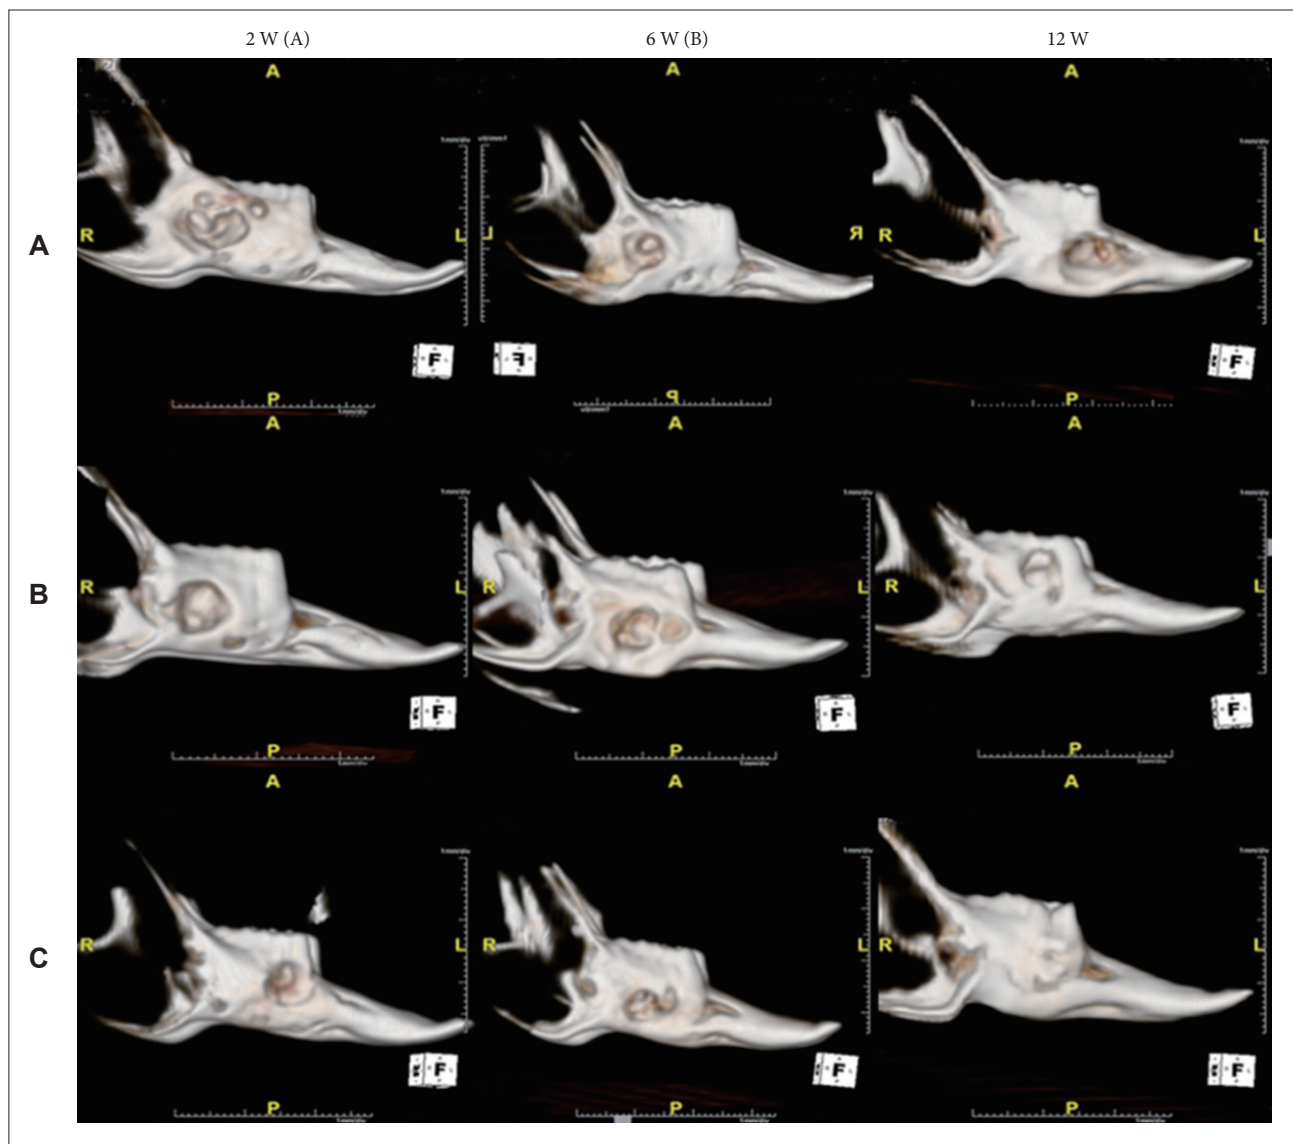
Representative images of three-dimensional CT reconstruction of the mandible bone at the different stages. (A) Hydrogel alone. (B) Hydrogels+rhBMP2. (C) Hydrogels/GMs+rhBMP2. rhBMP2: recombinant human bone morphogenic protein-2, GMs: gelatin microspheres.
